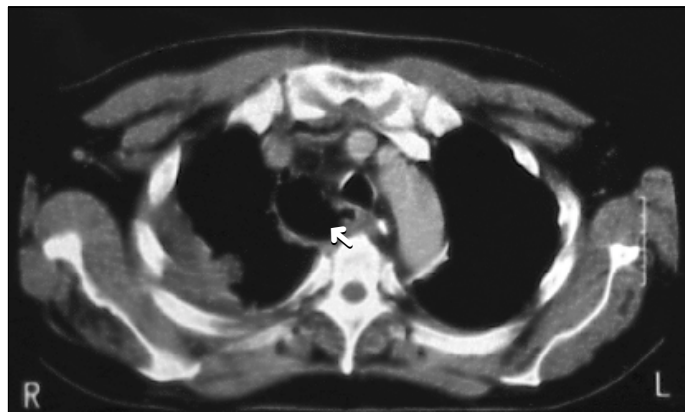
CT scan of chest showing air dissection in the mediastinum (arrow).
